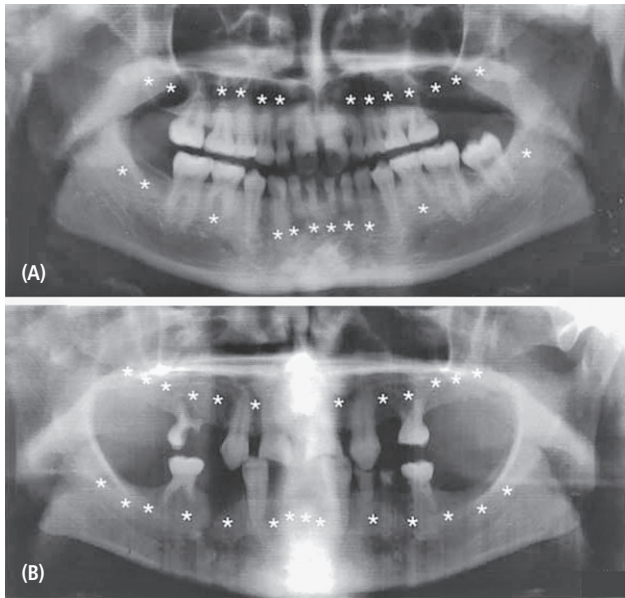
Panoramic radiographs of the proband (Case 3) at age 15 years (A) and her uncle at age 34 years (B). Stars indicate congenitally missing permanent teeth. Note that both family members have many persisting deciduous teeth.
